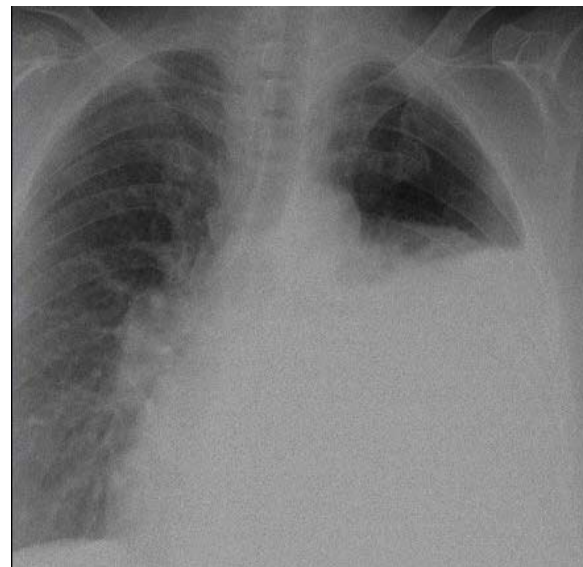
Chest radiography: Opacity was present in the middle and lower zones of the left lung.
